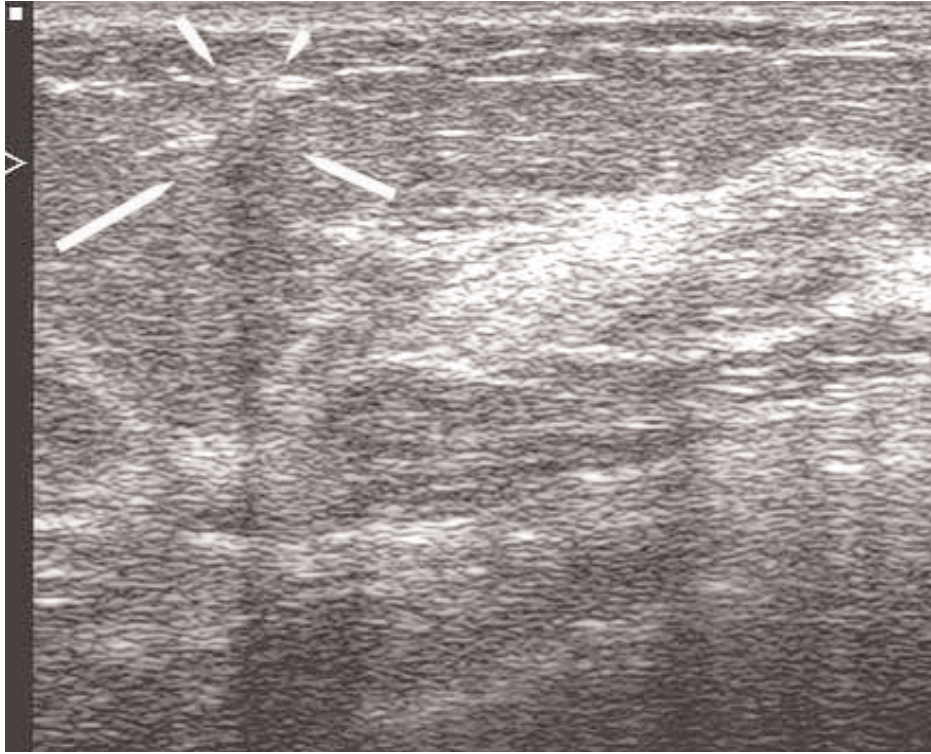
At Ultrasonography, only part of the lesion was visible as a slight architectural distortion with an element of posterior acoustic shadowing (arrows)
